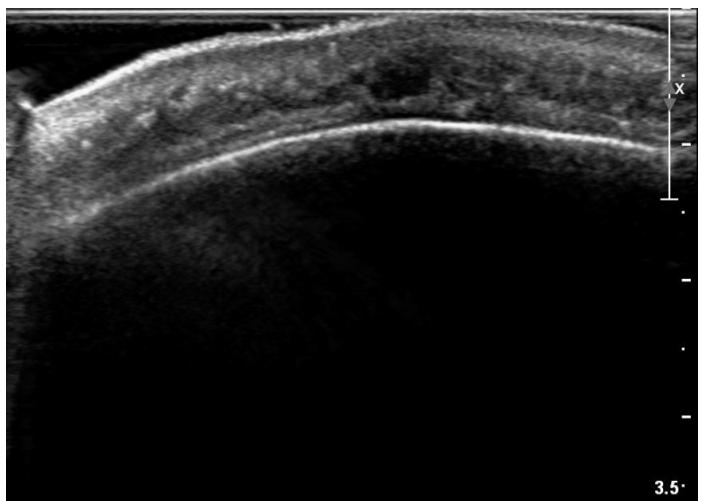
Ultrasound image showing normal cortical bone and trabecular bone.
